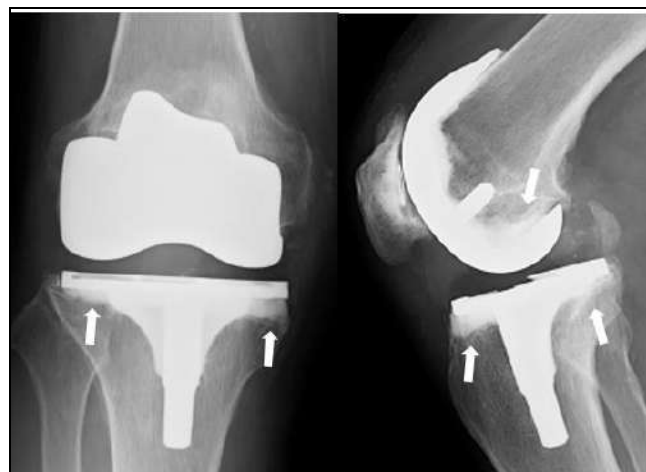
On November 20, 2017, X-ray images of his right knee joint showed a radiolucent zone under the medial baseplate of the tibial component (white arrow), but no noticeable change was observed compared with that taken last year
